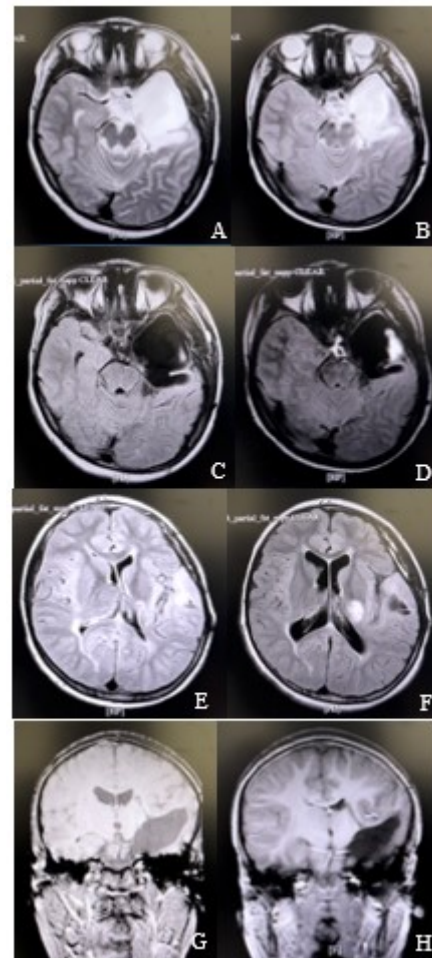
Postoperative (3 days) MRI head without IV contrast in axial T2 (A), T2-weighted FLAIR (C), and sagittal T1 (E) views. Follow-up (9 months) MRI head without IV contrast in axial T2 (B), T2-weighted FLAIR (D), and sagittal T1 (F) views showed a reduction in arachnoid cyst and ventricular system. Compared to the previous MRI, the size of the cystic parenchymal defect appeared slightly reduced (A-D), the ventricular system appeared smaller (E-H), and a midline shift to the left was observed (E, F)
